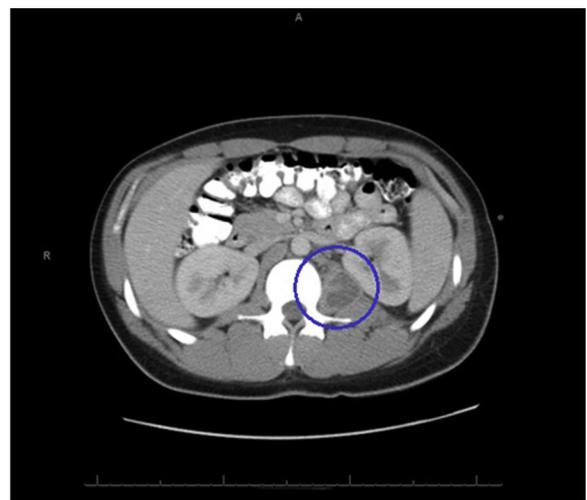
Computed tomography of the abdomen with psoas abscess indicated by the blue circle.
